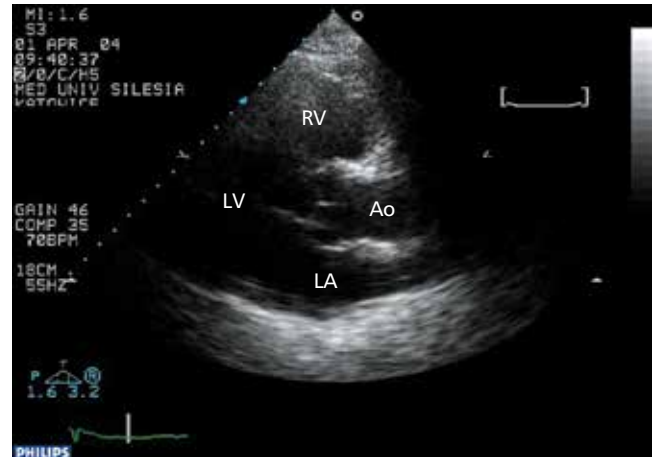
Transthoracic echocardiography. Parasternal long-axis view. Thickening of the ascending aortic wall, normal diameter of the aorta and aortic valve annulus. LV – left ventricle, RV – right ventricle, LA – left atrium, Ao – aorta
